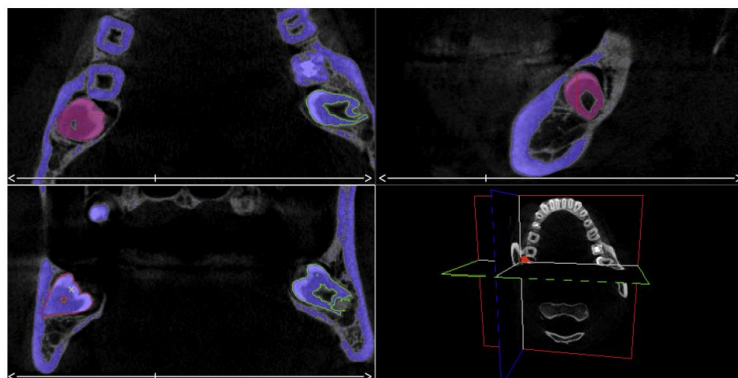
Separación del diente donante en el CBCT para planificación preoperatoria (40)
